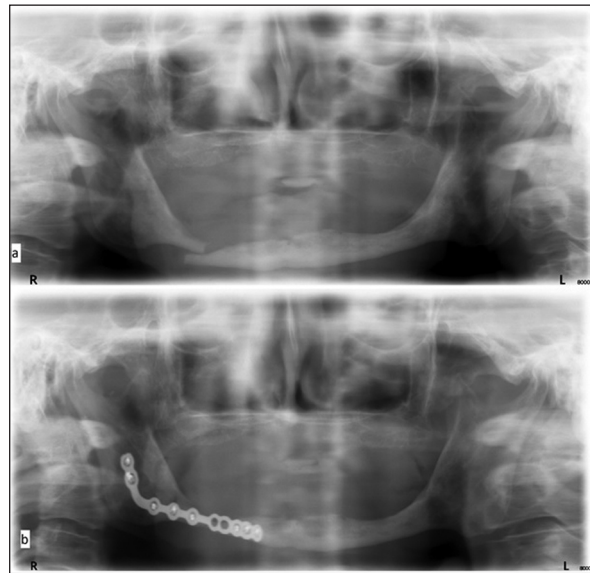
Preoperative (a) and postoperative (b) orthopantomogram of atrophic fracture of mandible.
